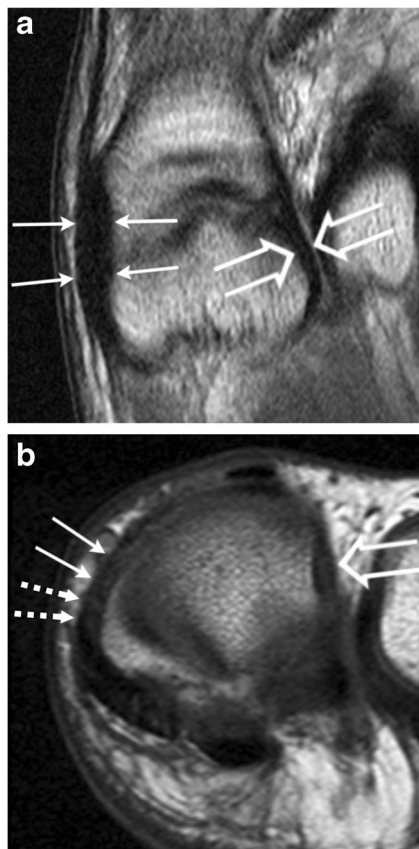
37-year-old male volunteer with hypointense medial and lateral collateral ligament complex. The medial accessory medial collateral ligament (*arrows*) and accessory lateral collateral ligament (*open arrows*) demonstrate purely hypointense signal characteristics on a coronal intermediate-weighted MR image (A). The medial collateral ligament (*arrows*), accessory medial collateral ligament (*dotted arrows*) and lateral collateral ligament (*open arrow*) is hypointense on a transverse T1-weighted MR image (B)
